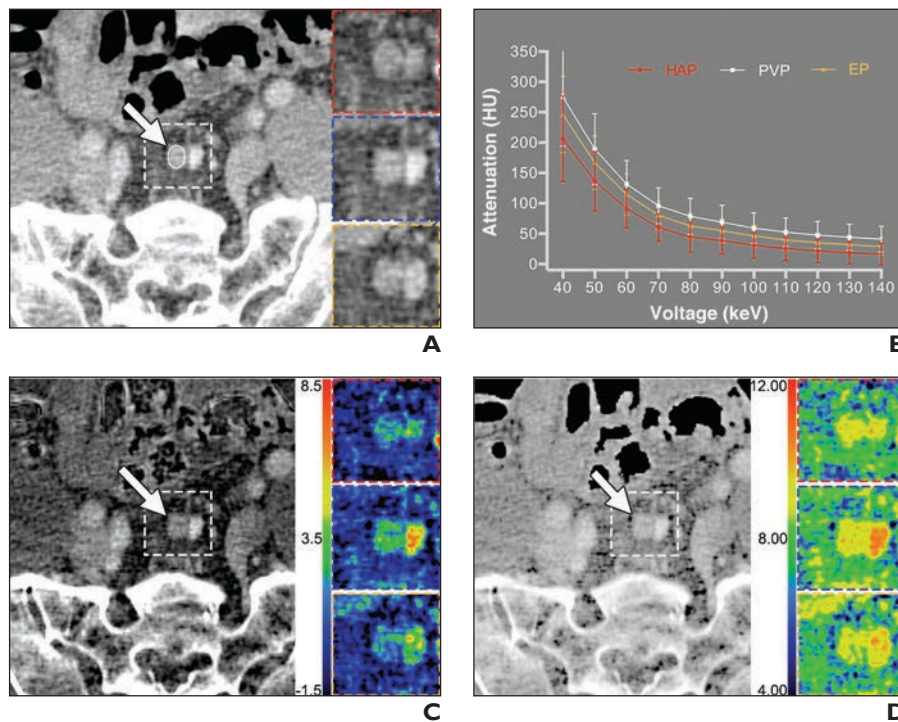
63-year-old man with moderately differentiated pathologic T2N0 rectal adenocarcinoma. Representative dual-energy CT examination of nonmetastatic lymph node. Dashed line indicates location of inserts. Inserts show hepatic arterial phase (red), portal venous phase (blue), and equilibrium phase (yellow) images.
